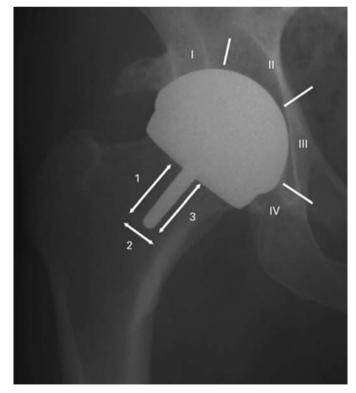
AP radiograph hip demonstrating zones 1, 2 and 3 around the peg of a hip resurfacing arthroplasty implant as described by Amstutz et al.²⁵
